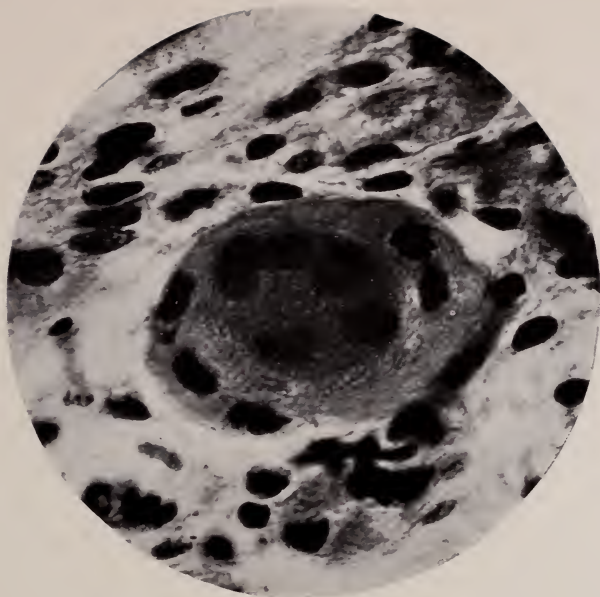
THIS CELL DID NOT ELONGATE, BUT IN OTHER RESPECTS IT WENT THROUGH A COMPLETE DIFFERENTIATION
